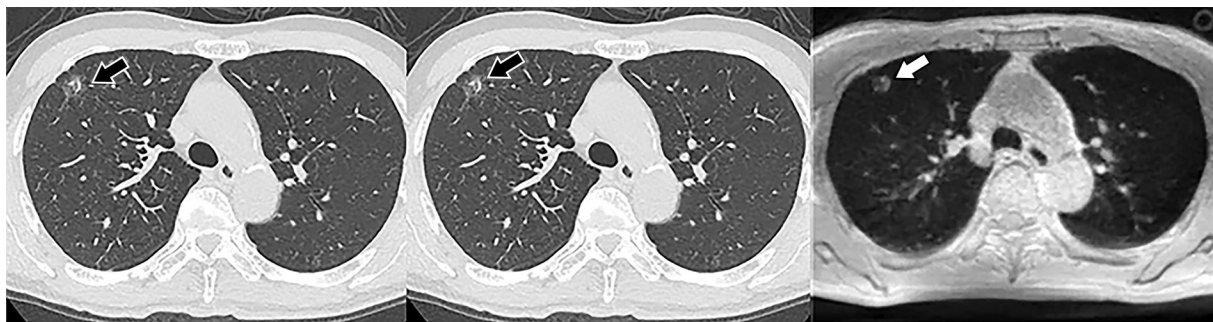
Images in a 63-year-old man with ground-glass nodule (arrow) who was diagnosed with minimally invasive adenocarcinoma. Unenhanced standard-dose (left) and low-dose (middle) CT scans in axial plane clearly show a ground-glass nodule with a long-axis diameter of 13 mm in the right upper lobe. In addition, unenhanced pulmonary MRI scan with ultrashort echo time (repetition time msec/echo time μ sec, 4.0/96; flip angle, 5°) (right) demonstrates the presence of a ground-glass nodule with a long-axis diameter of 9 mm. Both reviewers evaluated this nodule as ground-glass nodule and assessed it as Lung CT Screening Reporting and Data System category 2.
